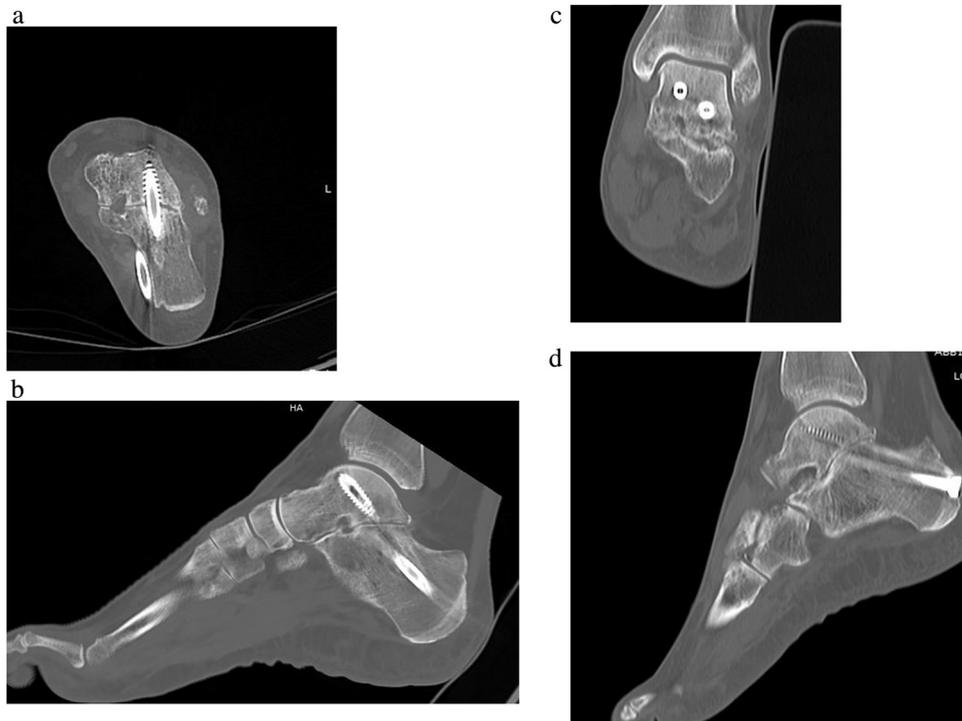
(a & b) Patient 18. Axial and Sagittal CT at 3 months confirmed a delayed union of subtalar arthrodesis and LIPUS was started. She completed 6 months of LIPUS treatment but Coronal and Sagittal CT (c & d) at 9 months confirmed a nonunion. She went on to have a successful revision surgery with removal of metalwork, bone graft and revision arthrodesis.
